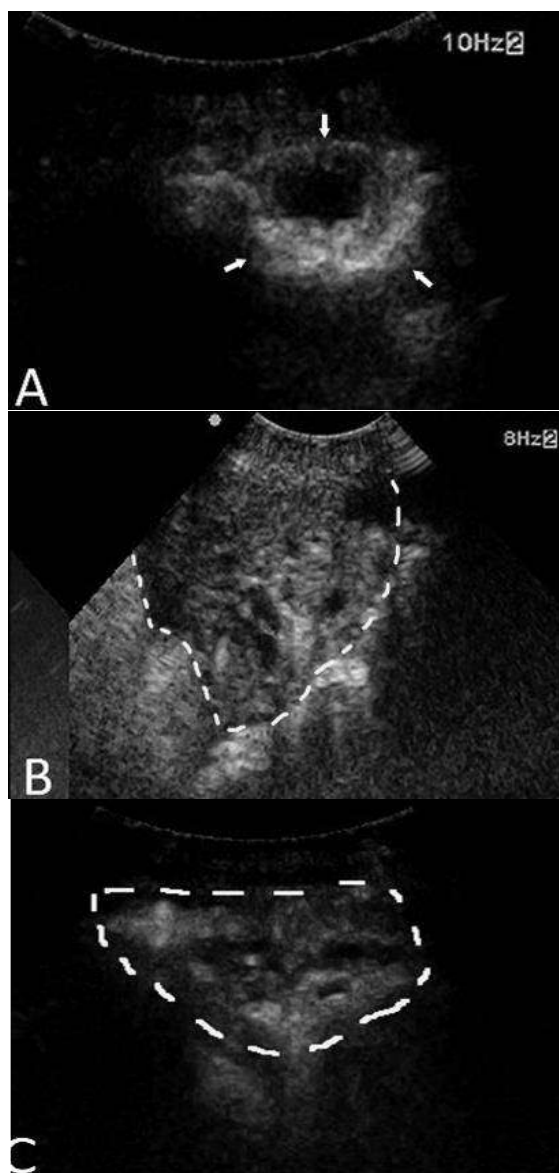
Tuberculoma ultrasound pattern after contrast administration. A) Rim enhancement; B) Homogeneous enhancement; C) Heterogeneous enhancement¹
